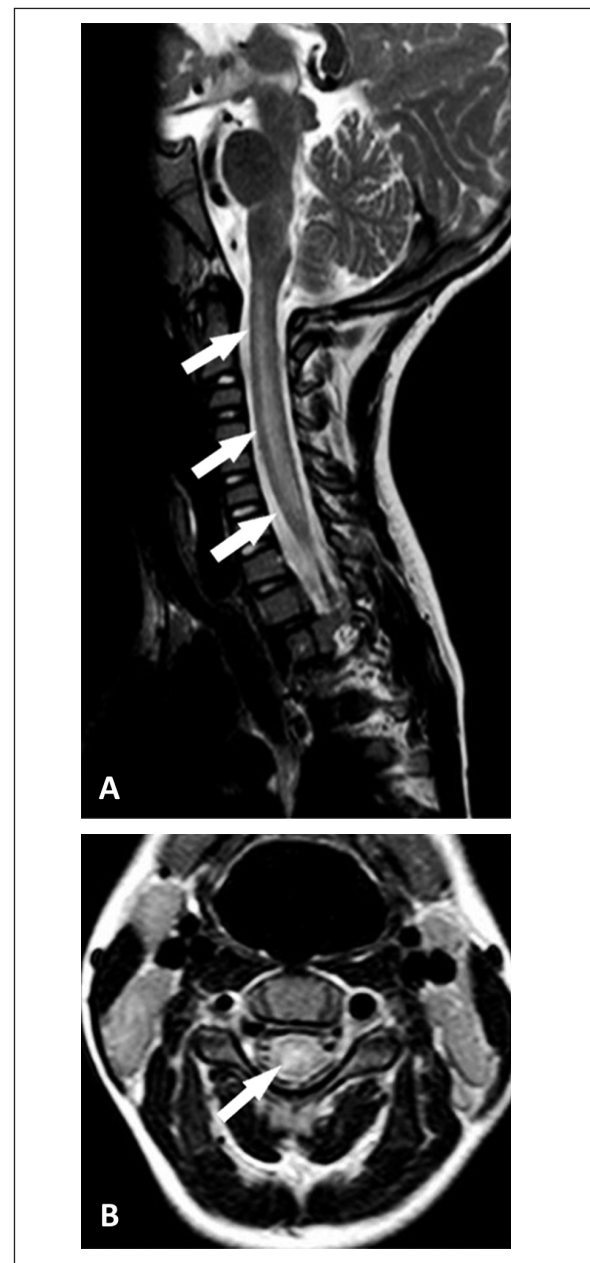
MRI findings in the acute phase of acute flaccid myelitis. A. Sagittal T2 at admission of case 1 with hyperintensity of the grey matter from C1 level to C7 (arrow) B. Axial T2 image showing hyperintensity of the grey matter.
